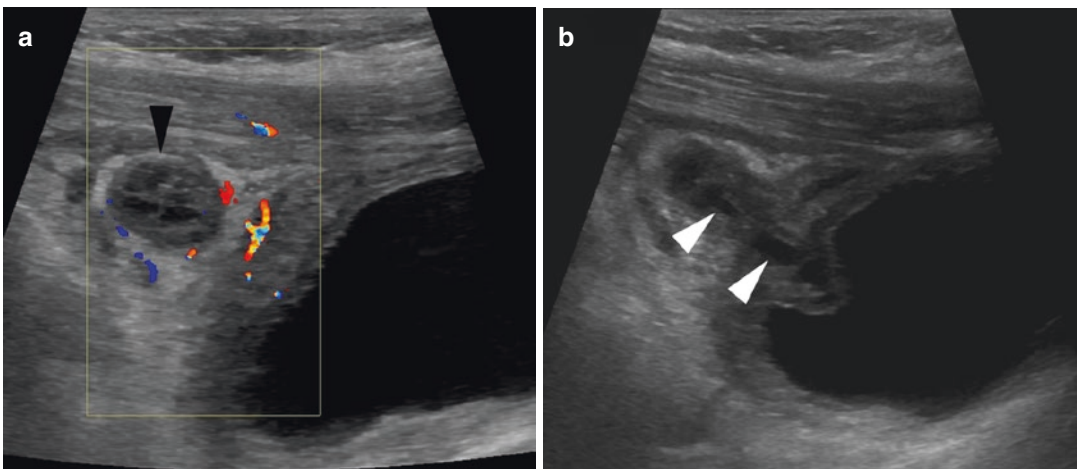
UTI related to pyourachus. Para-sagittal sonogram (a) shows a heterogeneous and echogenic mass corresponding to a pyourachus (black arrowhead) just above the bladder with peripheral hyperechoic fat
